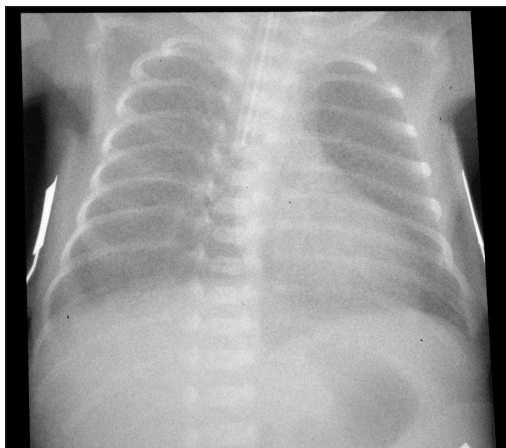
Chest radiograph of the same infant as in Figure 2, still requiring mechanical ventilation at 5 weeks of postnatal age, showing typical features of chronic lung disease of prematurity. Hyperlucent areas represent patchy emphysematous changes (best seen in the left lower lobe) and areas of lung fibrosis and collapse (right upper lobe).
